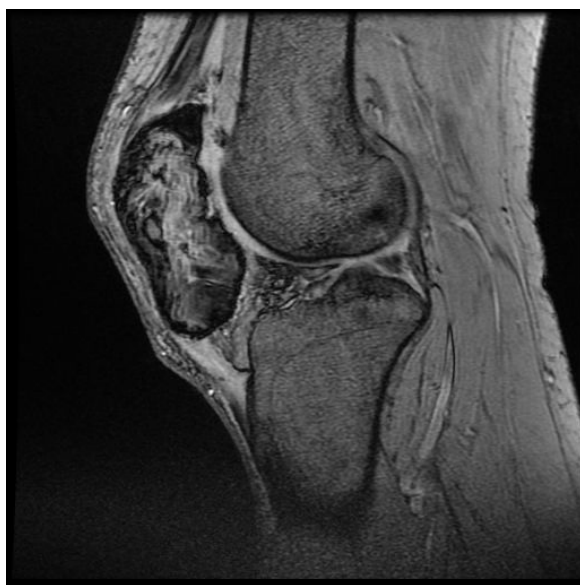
Presurgical MRI evaluation of the affected knee
